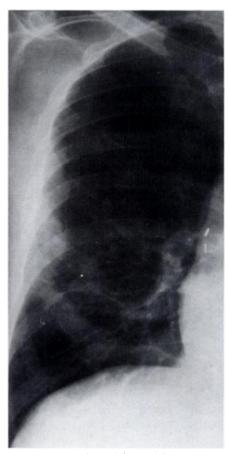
Nonclassical form of disease in an elderly woman without other medical problems, who for several years had a nonproductive cough and fatigue. Sputum cultures were repeatedly positive for MAC infection. Radiograph of the right lung demonstrates multiple nodular and linear opacities in the middle and lower lobe. Similar findings were seen in the left lung. No upper lobe disease was present.
